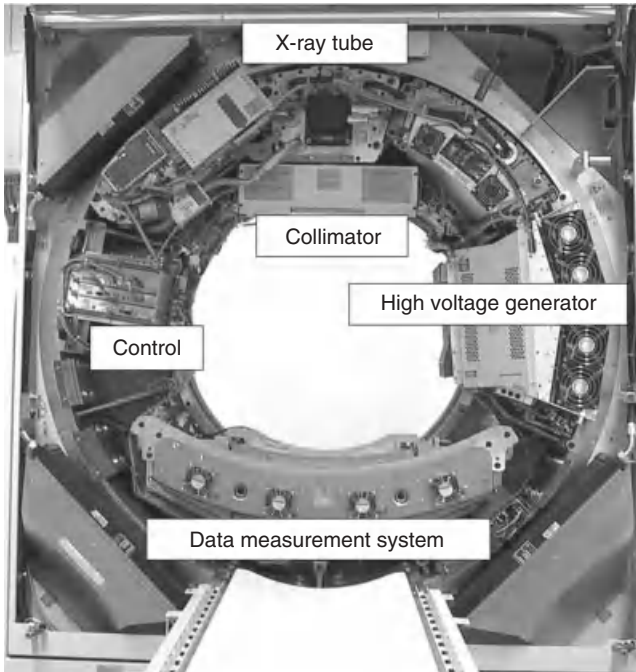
Basic system components of a modern “third-generation” CT system. First-generation systems used a collimated pencil beam and therefore required a translation of the pencil beam and the single detector element before each rotational step to scan the whole object. Second-generation scanners used a small fan beam but still required translational and rotational patterns of the X-ray source and the small detector array, whereas the fan beam of third-generation scanners covered the whole object the first time and allowed for a pure rotational motion of the tube and the detector around the patient.
